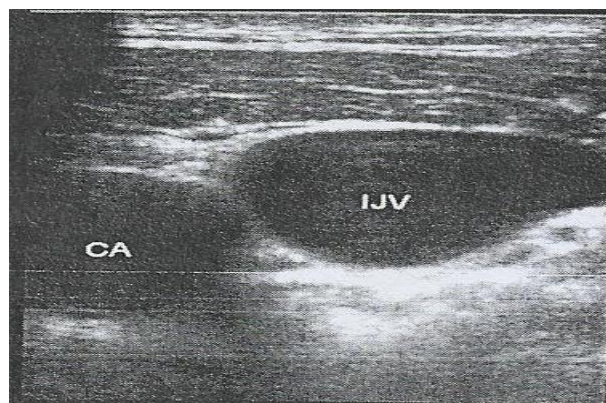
Ultrasound image showing anterolateral relationship of right internal jugular vein with right common carotid artery from the data collected
